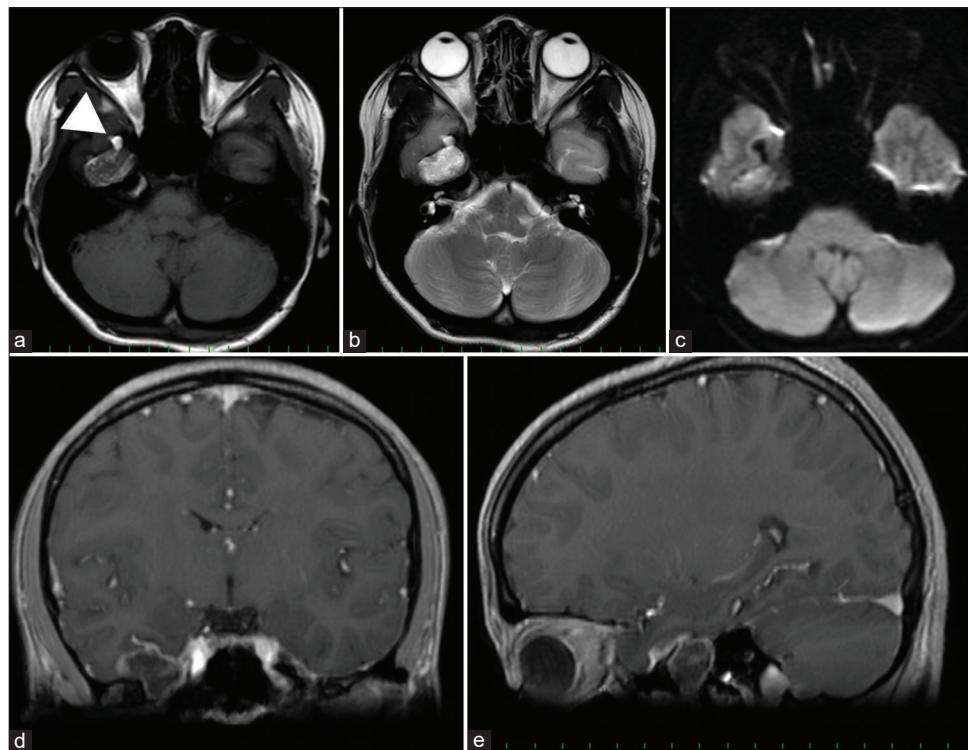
Initial magnetic resonance imaging MR images show hypointense in T1 (a), hyperintense in T2 (b), with restricted diffusion on DWI (c). Fat droplets in the subarachnoid space nearby the tumor was also noted (arrowhead). (d and e): The coronal and sagittal images with gadolinium shows the slight enhancement of the tumor capsule and also the mass locating both intradurally and extradurally at foramen ovale.
